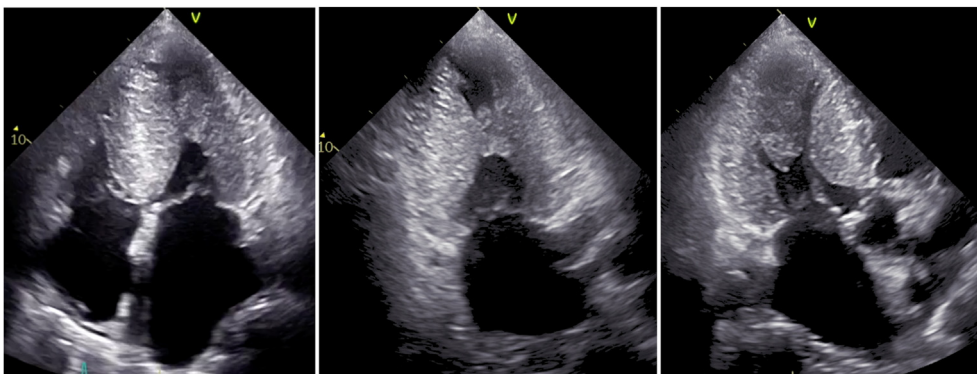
Transthoracic echocardiogram with severe left ventricular hypertrophy.
